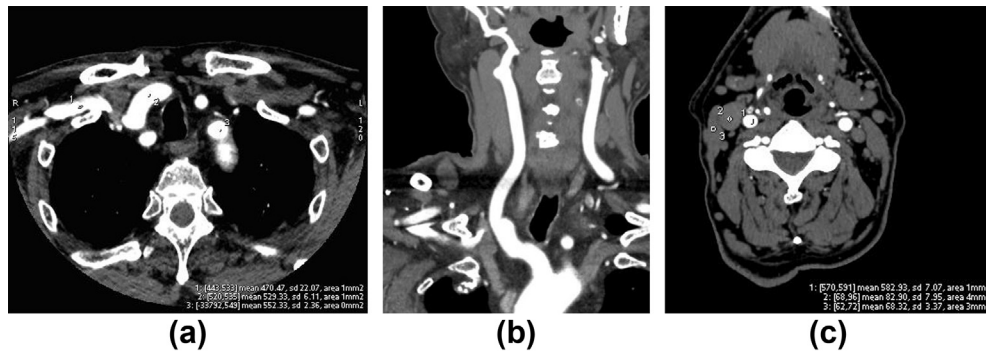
CTA in a 58-year-old man (weight 85 kg; the heaviest patient in this study), using a 40 ml contrast medium dose, 5 ml/s injecting speed, 80 kV, and 600 mAs. (a) Attenuation of the peripheral venous streak artefacts was 470.47 HU, lower than that of the innominate artery (529.23 HU). (b) Peripheral venous streak artefacts have no effect on the visualization of the right common carotid artery. (c) The attenuation values (582.93 HU, 517.87 HU) of the common carotid artery were good. The attenuation of the internal jugular vein was below 100 HU, and was little affected by venous streak artefacts, with a qualitative image score of 5.
